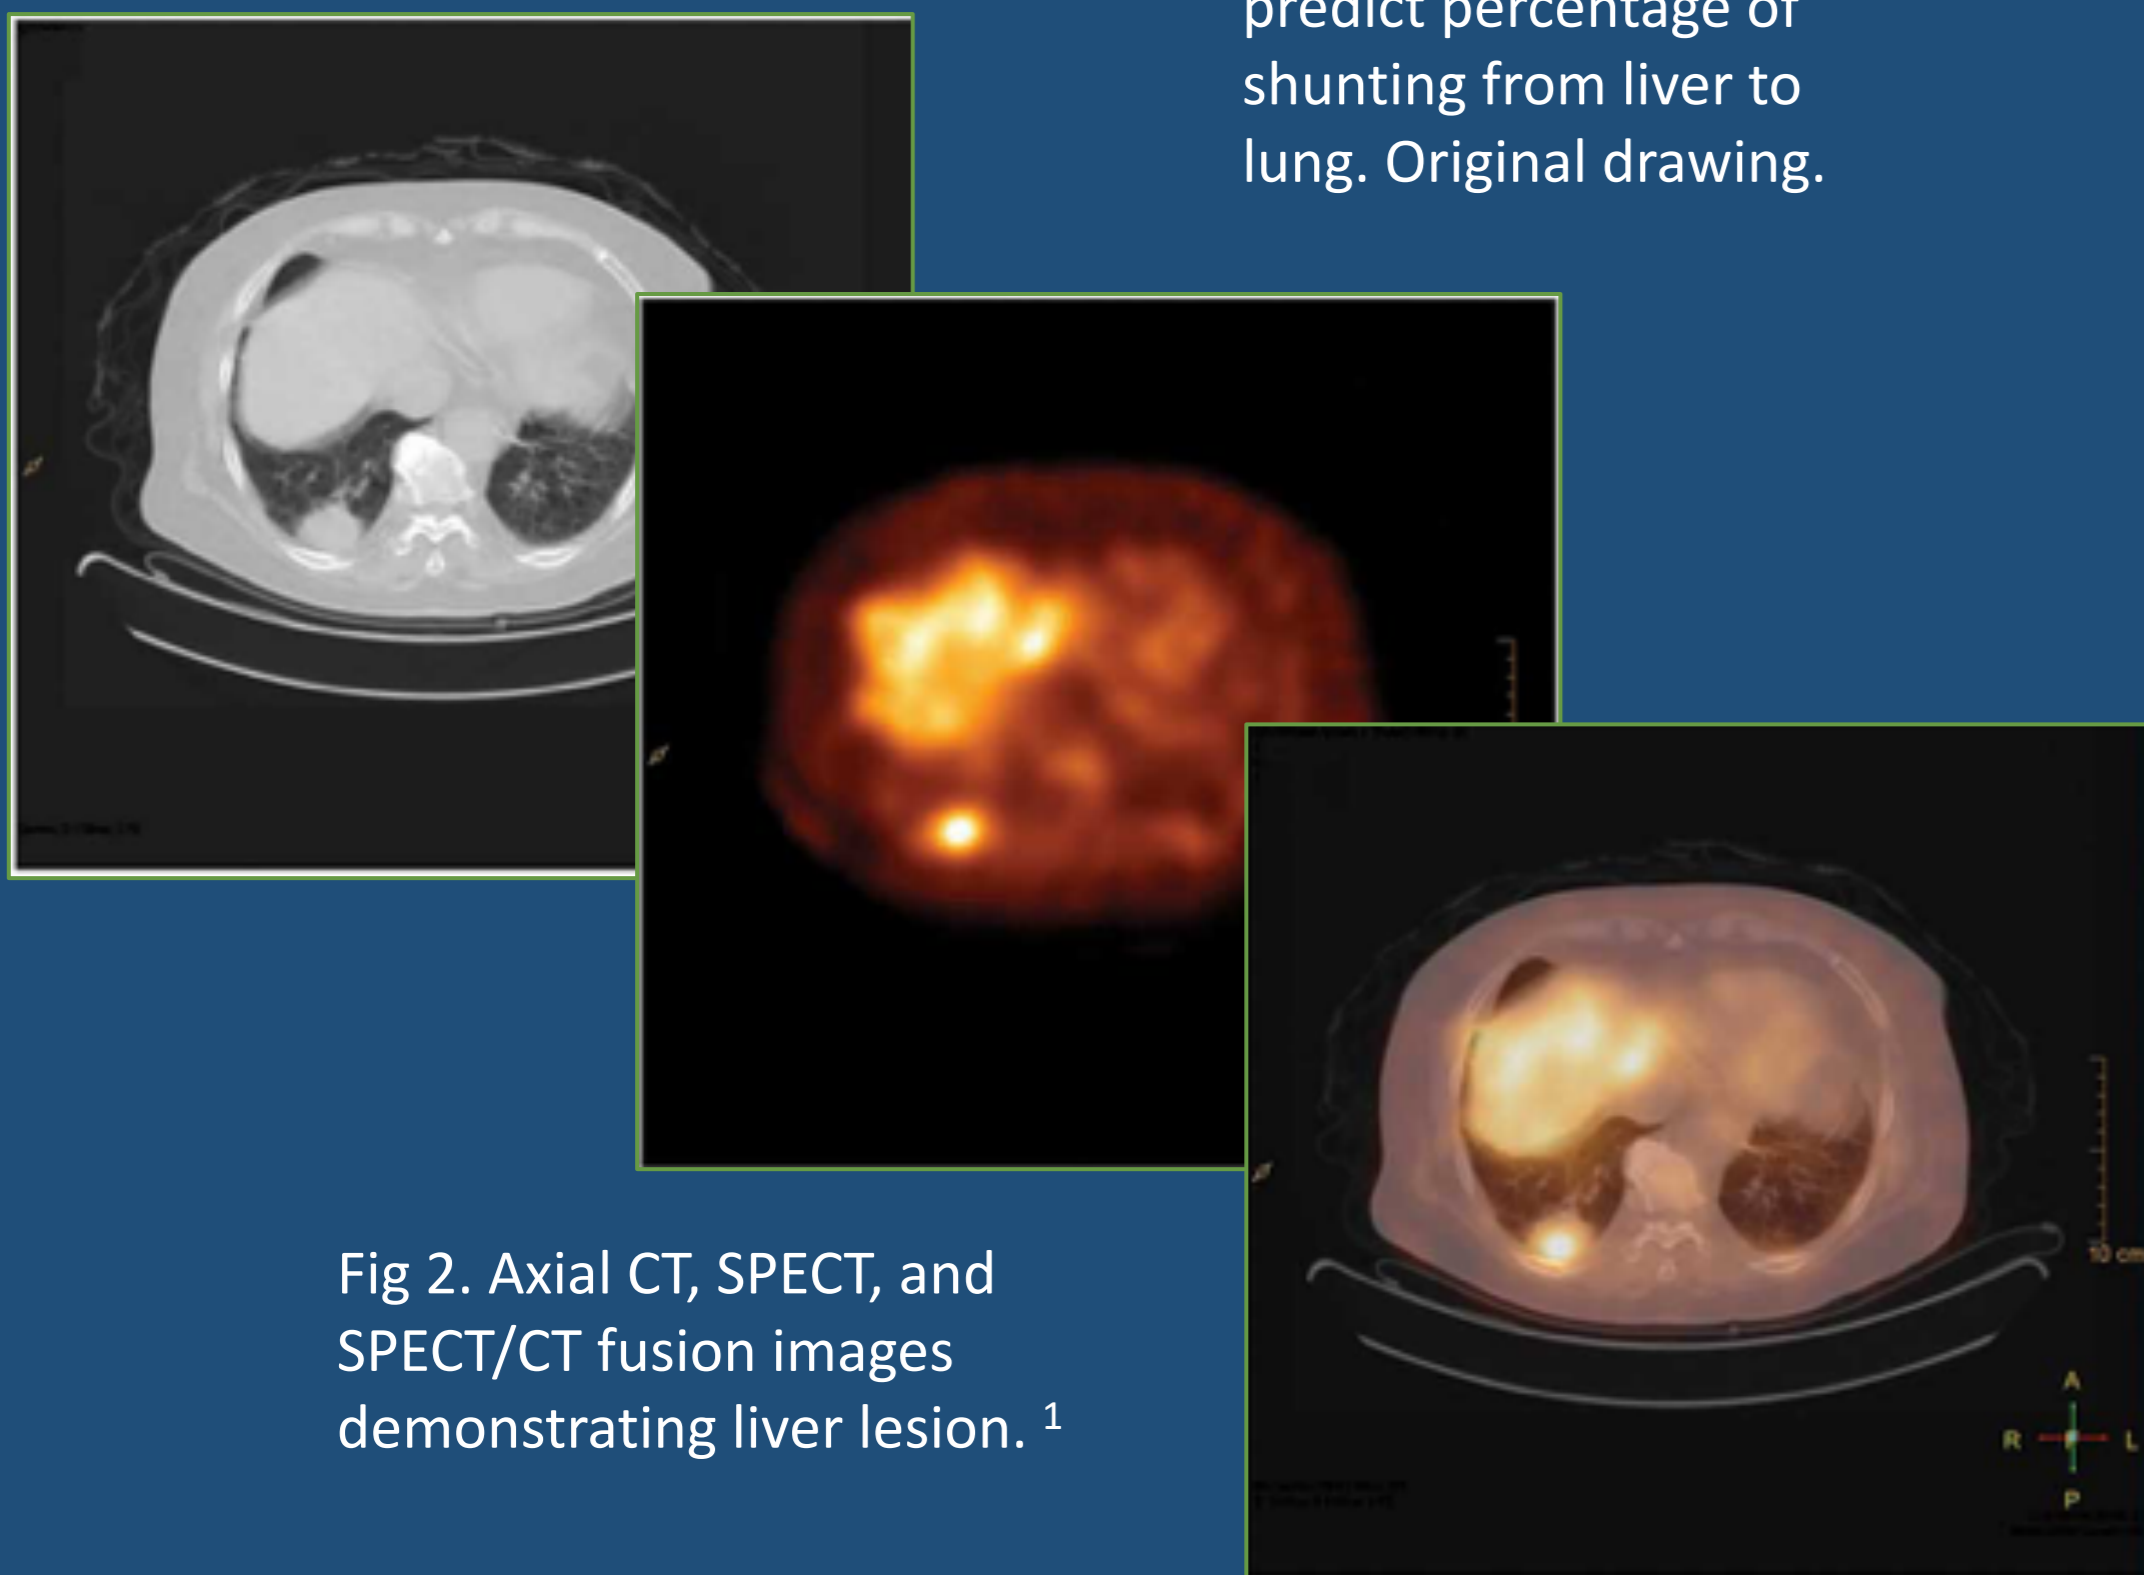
Axial CT, SPECT, and SPECT/CT fusion images demonstrating liver lesion.¹
